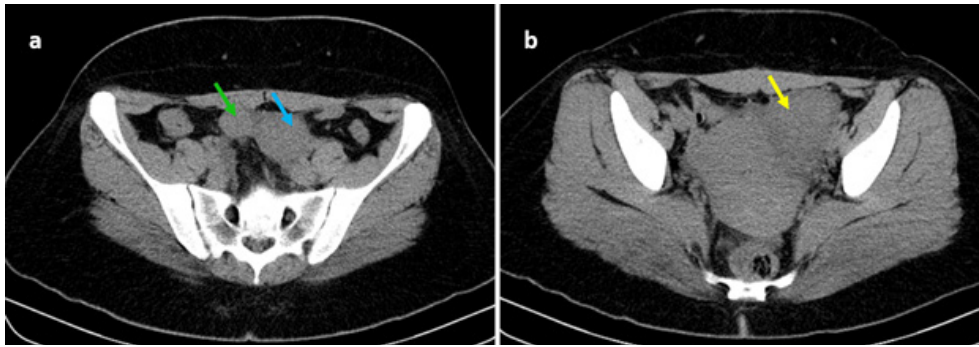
Axial computed tomography without intravenous contrast administration shows three peritoneal soft-tissue density tumors in the pelvic cavity: one near the left para-uterine margin (yellow arrow), and the other two located superiorly, one on the right (green arrow) and the other more central (blue arrow).
